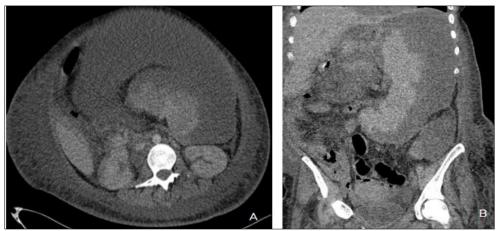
Non-enhanced axial (A) and coronal (B) CT scan showing mild splenomegaly and multiple low attenuation areas in the periphery of the spleen.
